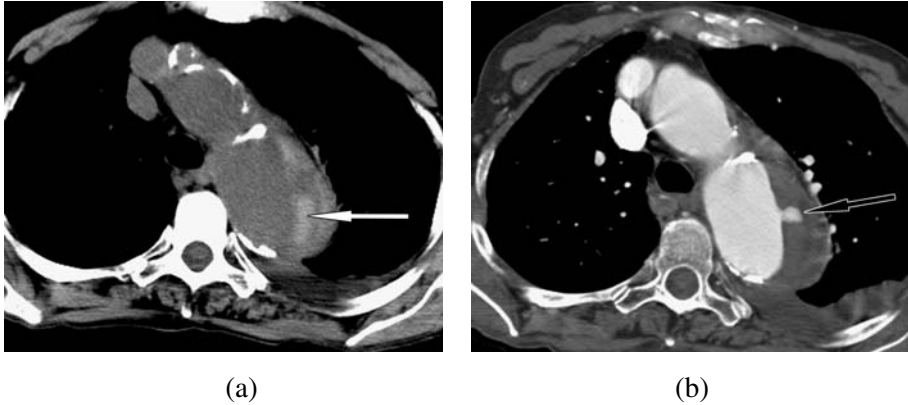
Axial CT images of penetrating atherosclerotic ulcer with acute intramural hematoma in the aortic arch: (a) unenhanced image shows high attenuation intramural hematoma (white arrow); (b) contrast-enhanced image shows focal contrast outpouching of the true lumen, consistent with penetrating ulcer (black arrow).
